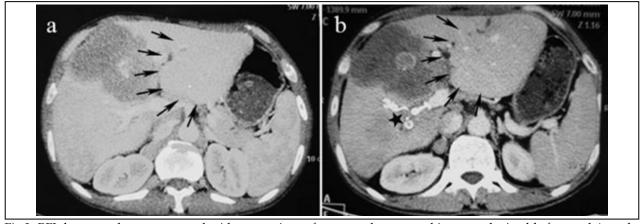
RFL hypertrophy was assessed with comparison of computed tomographic scans obtained before and 4 weeks after PVE (FLR: from 347 to 682 cm3). Comparison of the arrow in (a) vs (b) indicates enlargement of the left segment of the liver. The black star in (b) shows high density (coil) in the right branch of portal vein.
